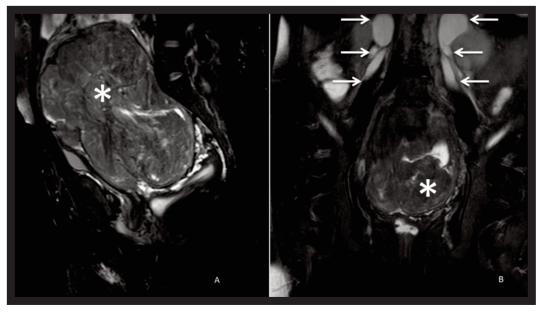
Sagittal (A) and coronal (B) magnetic resonance images show multilobulated huge cervical mass (*asterisks*) filling the pelvis and causing bilateral hydroureteronephrosis (*arrows*).
